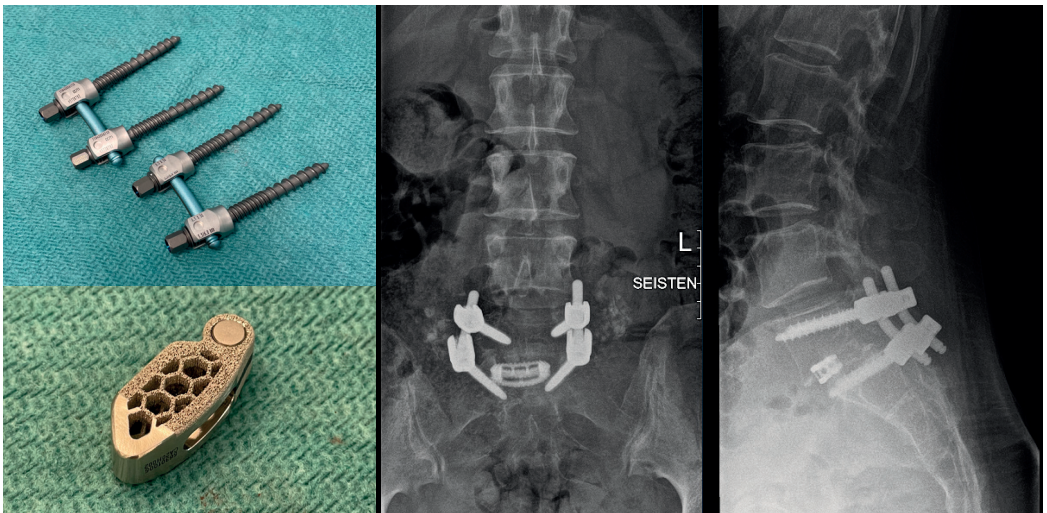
Example of pedicle screw instrumentation and a TLIF spacer for a single level fusion. Radiographs showing L5–S1 fusion for isthmic spondylolisthesis.
